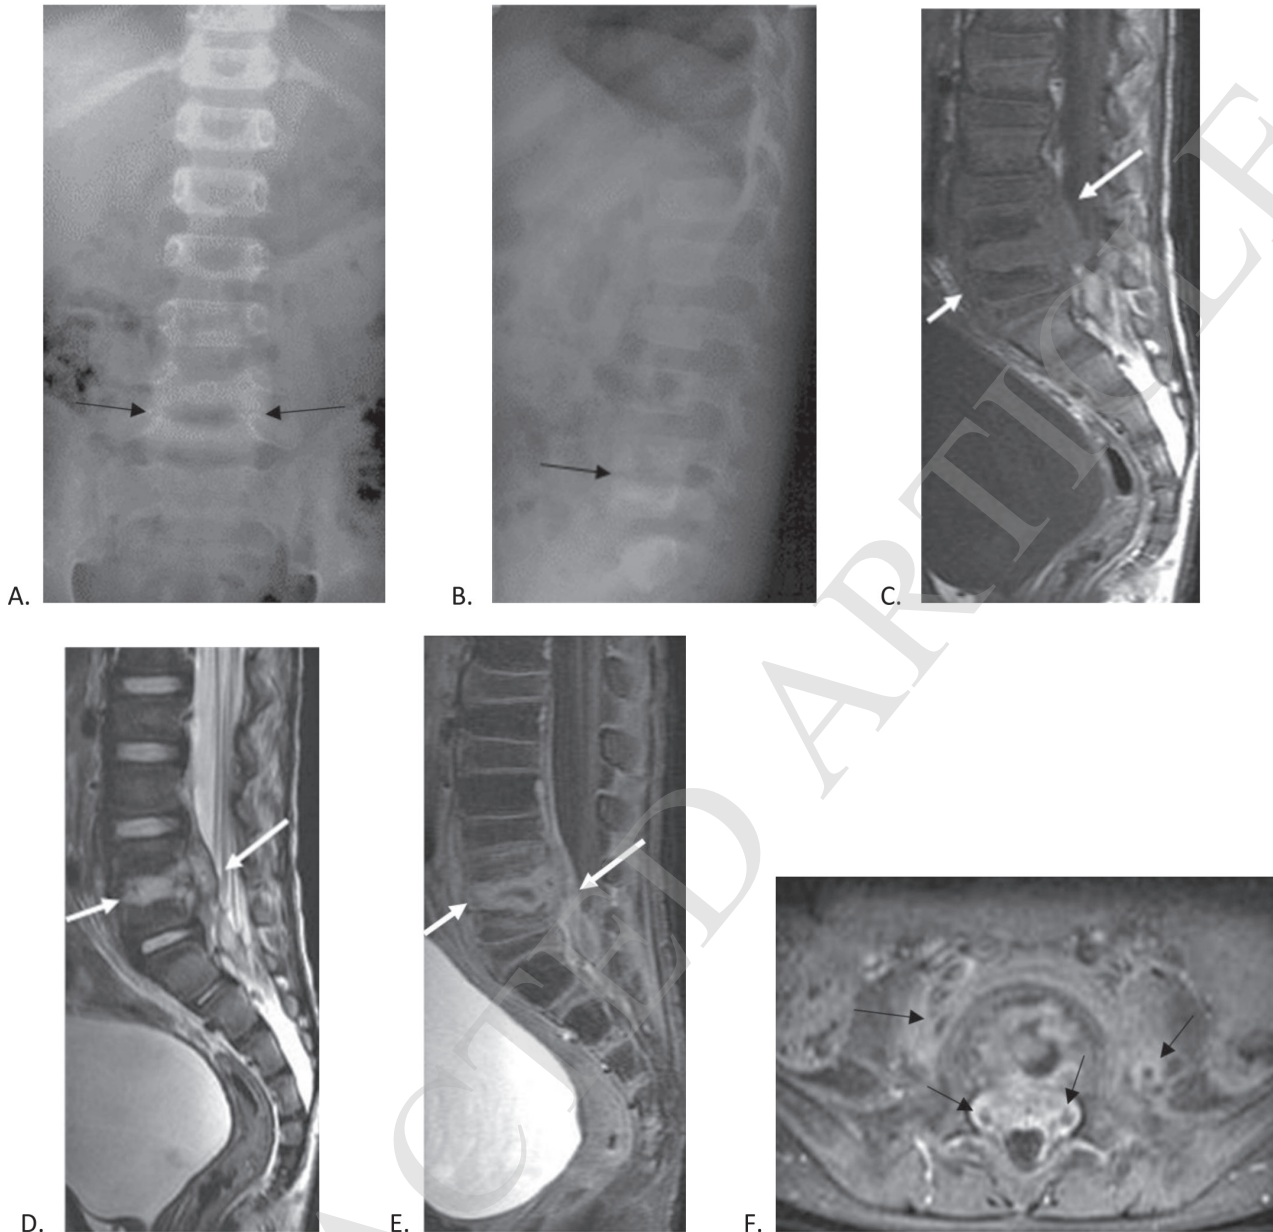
Pyogenic spondylodiscitis. A 5-year-old boy, known case of acute nonlymphocytic leukemia (ANLL) post bone marrow transplant presented with low back pain for 4 days without fever. Anteroposterior (A.) and lateral (B.) plain radiographs show narrowing of the L4-5 disc space with subtle irregularity of the adjacent endplates (black arrows). C. T1-weighted sagittal MRI shows diffuse T1 hypointensity of the visualized vertebral bodies with destruction of the L4 and L5 vertebral bodies (white arrows). D. T2-weighted sagittal MRI demonstrates abnormal mild T2 hyperintensity in the L4-5 disc space and irregular destruction of the adjacent endplates with ventral epidural and anterior paraspinal soft tissue (white arrows). E. Postgadolinium, fat-saturated T1-weighted sagittal MRI reveals diffuse marrow enhancement of the L4 and L5 vertebral bodies as well as inhomogeneous enhancement of the L4-5 disc space (white arrows). Thick enhancing ventral epidural soft tissue (white arrows) and thin anterior paraspinal enhancement extending from lower L3 to upper S1 level is seen. F. Postgadolinium, fat-saturated T1-weighted axial MRI confirms the vertebral marrow enhancement, enhancing ventral epidural and paraspinal soft tissue. In this case, there are a few small rim enhancing portions (black arrows) in the anterior epidural and paraspinal soft tissue enhancement possibly representing small abscess formation. The blood cultures were positive for streptococci, and then he was treated for pyogenic spondylodiscitis with antibiotics.
